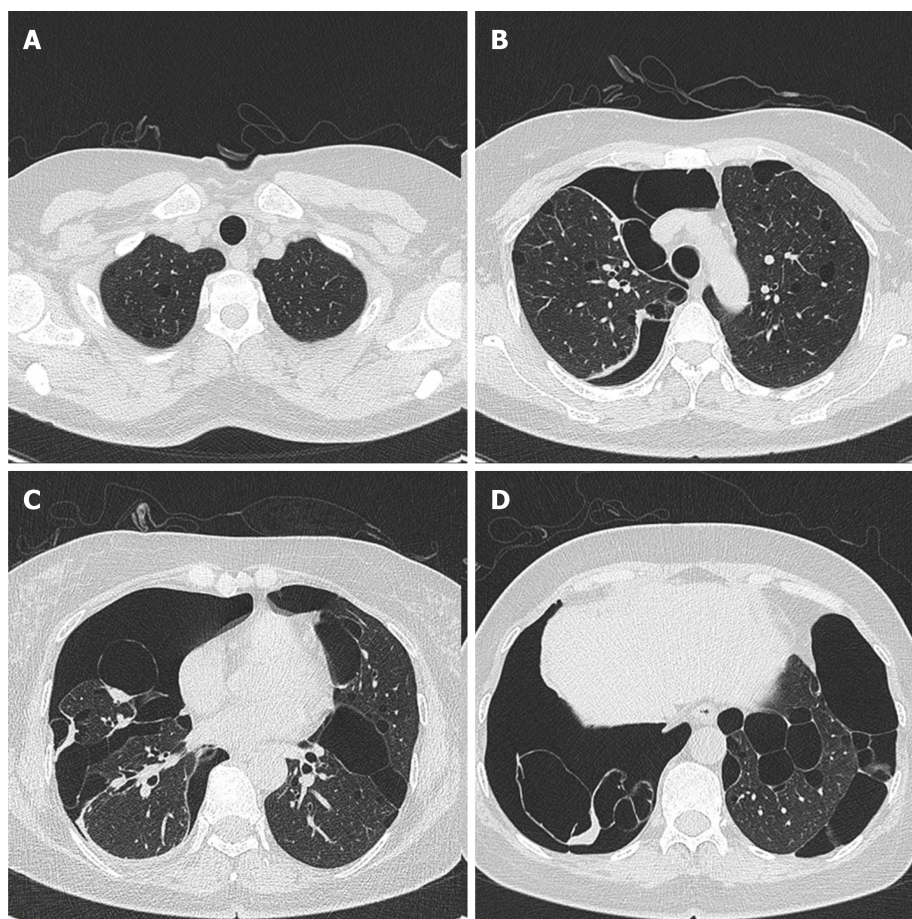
Axial computed tomography images. A: The patient's mother showed multiple thin-walled cysts in the apical segment of the right upper lobe; B: Irregular morphology cysts located in the upper-lung of both sides; C: Bilateral multiple lung cysts located at the level of the upper mediastinum; D: Right-sided pneumothorax and bilateral lung cysts located at both lung bases.
